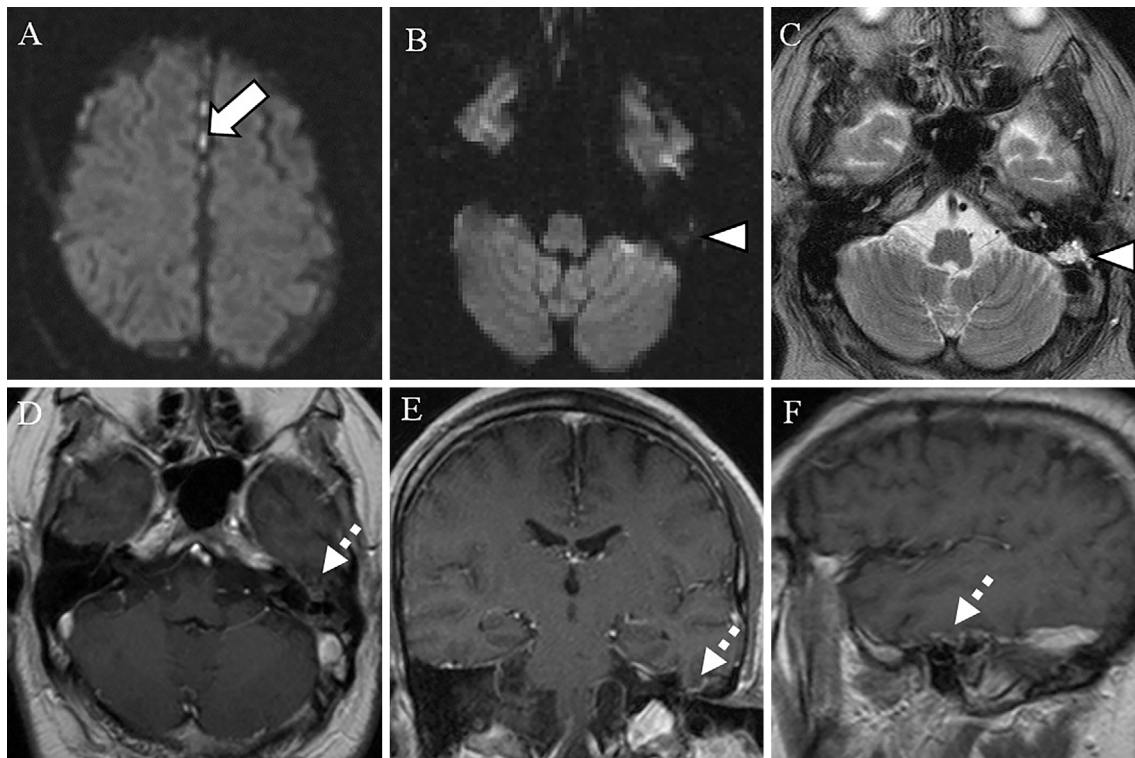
A: An axial diffusion-weighted image shows several spotty, high-intensity areas along with the cerebral falx, suggesting meningitis-related purulent material (white arrow). B, C: An axial diffusion-weighted image shows a faint high-intensity area, probably due to the T2 shine-through effect of mastoiditis, at the left mastoid cells, but no intense signal (restricted diffusion) suggesting cholesteatoma. An axial T2-weighted image reveals a high-intensity area at the left middle ear corresponding to otitis media (white arrowheads). D, E, F: The axial, coronal, and sagittal contrast-enhanced T1-weighted images show a minimal sac-like left temporal lobe protrusion into the petrous bone defect, suggesting a cephalocele (white-striped arrows).
